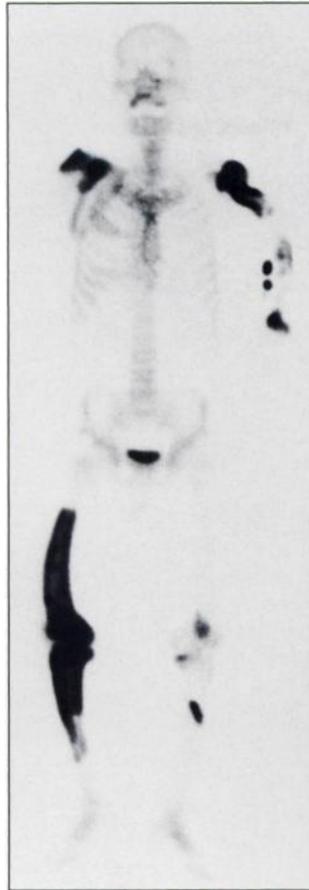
Technetium-99m-HMDP bone scintigraph shows markedly high accumulation at right leg, right scapula, right acromion, left shoulder, left wrist, left knee, left lower leg and left elbow and faint uptake in right third rib. The marked uptake at left elbow was concordant with the site of loosened intramedullary stem of the elbow prosthesis in the radius and ulna for the surgical treatment of pathologic fracture.
